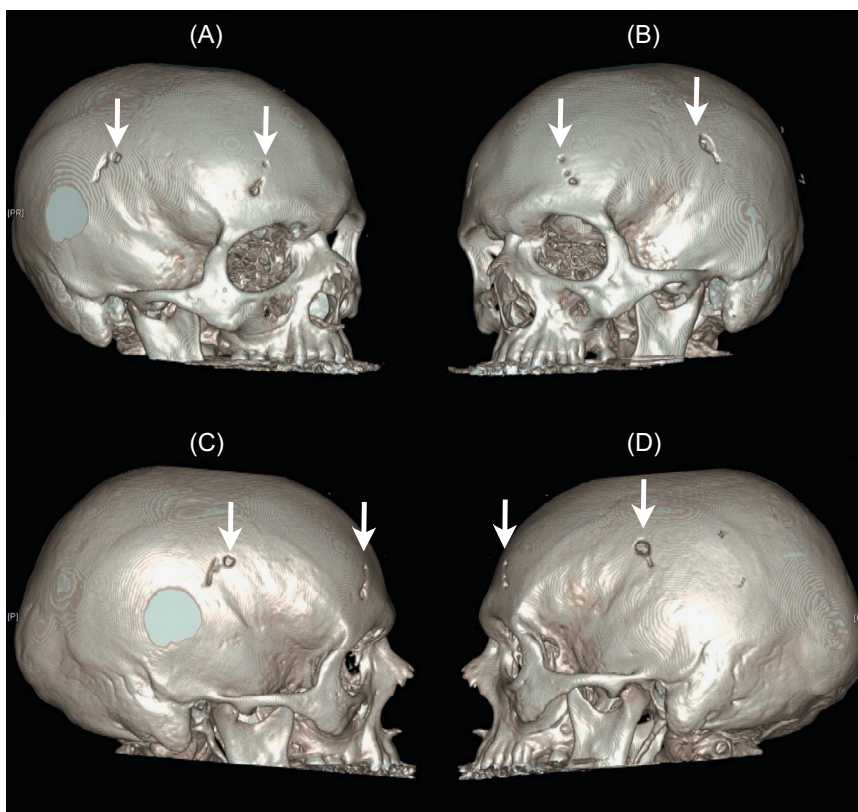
(A–D) Reconstructed 3-D CT images demonstrating sites of cranial penetration of halo pins.
